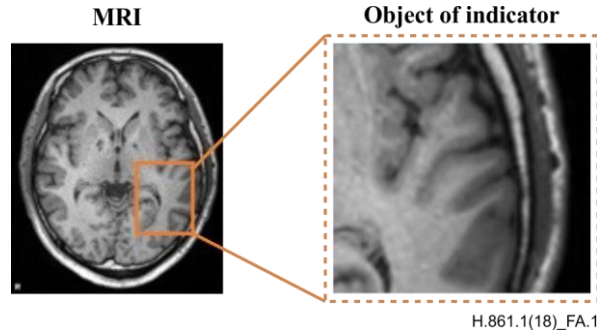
MRI image of GM
